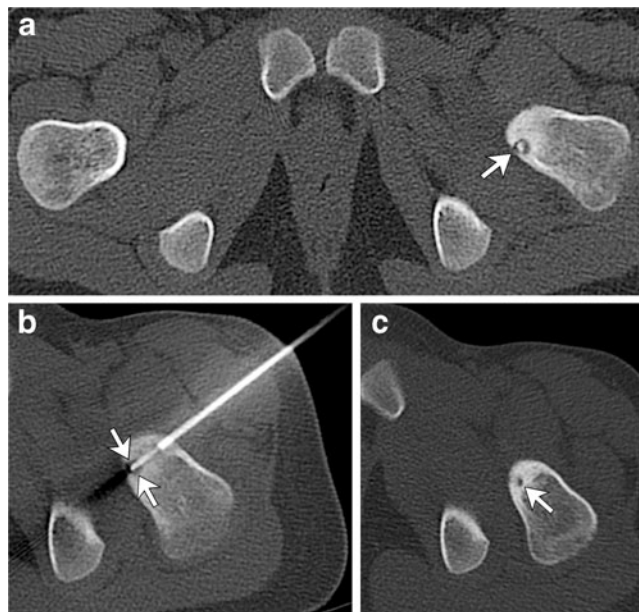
Treatment failure in a 7-year-old girl with hip pain. a Initial axial CT obtained after 4 months of hip pain, which was relieved by aspirin. There is central rounded lucency within the posterior left femoral neck that contains a calcified nidus consistent with an osteoid osteoma (arrow). b Axial CT image during radiofrequency ablation shows proper positioning of the electrode tip within the nidus (arrows). c Follow-up CT obtained 7 months after treatment for persistent hip pain shows residual rounded lucency within the femoral neck (arrow). The girl had a second radiofrequency ablation and has been symptom-free
